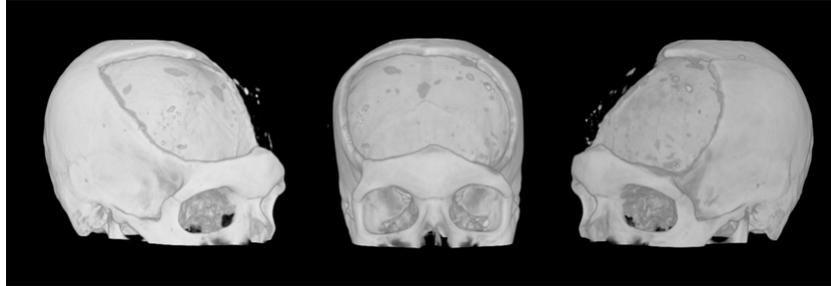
Case 1 - Patient's CT images from different angles.
